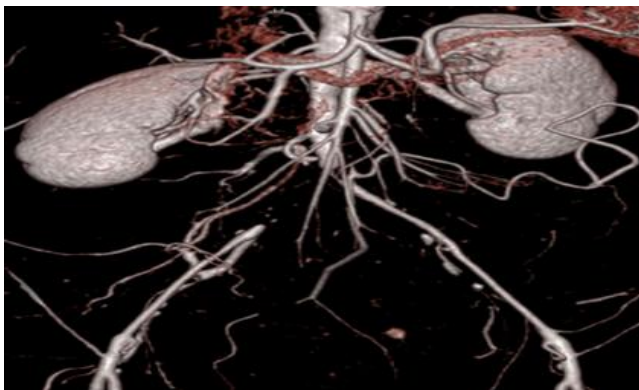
CT Angiogram of a 65 years old patient.
